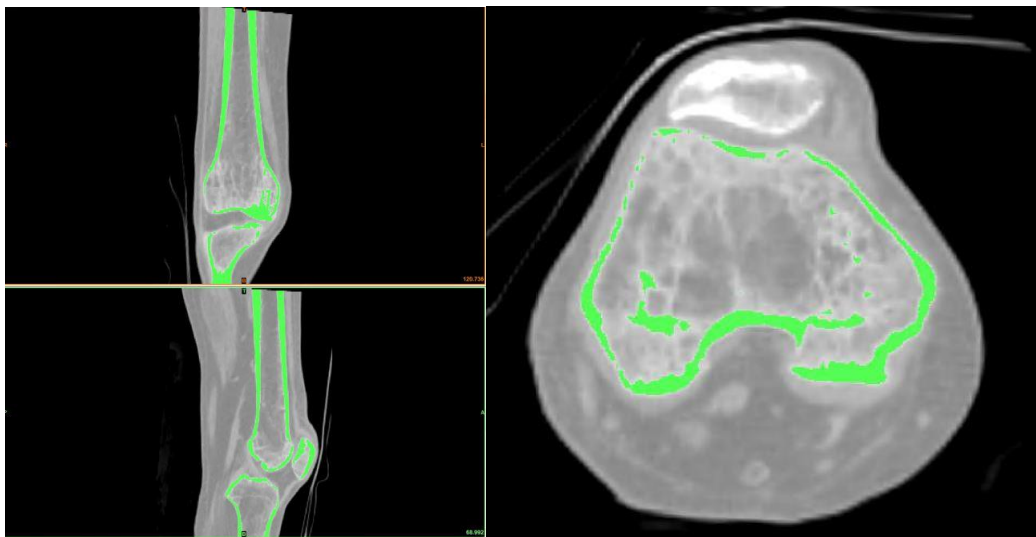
CT scans with thresholding without manual identification of periosteal surface
